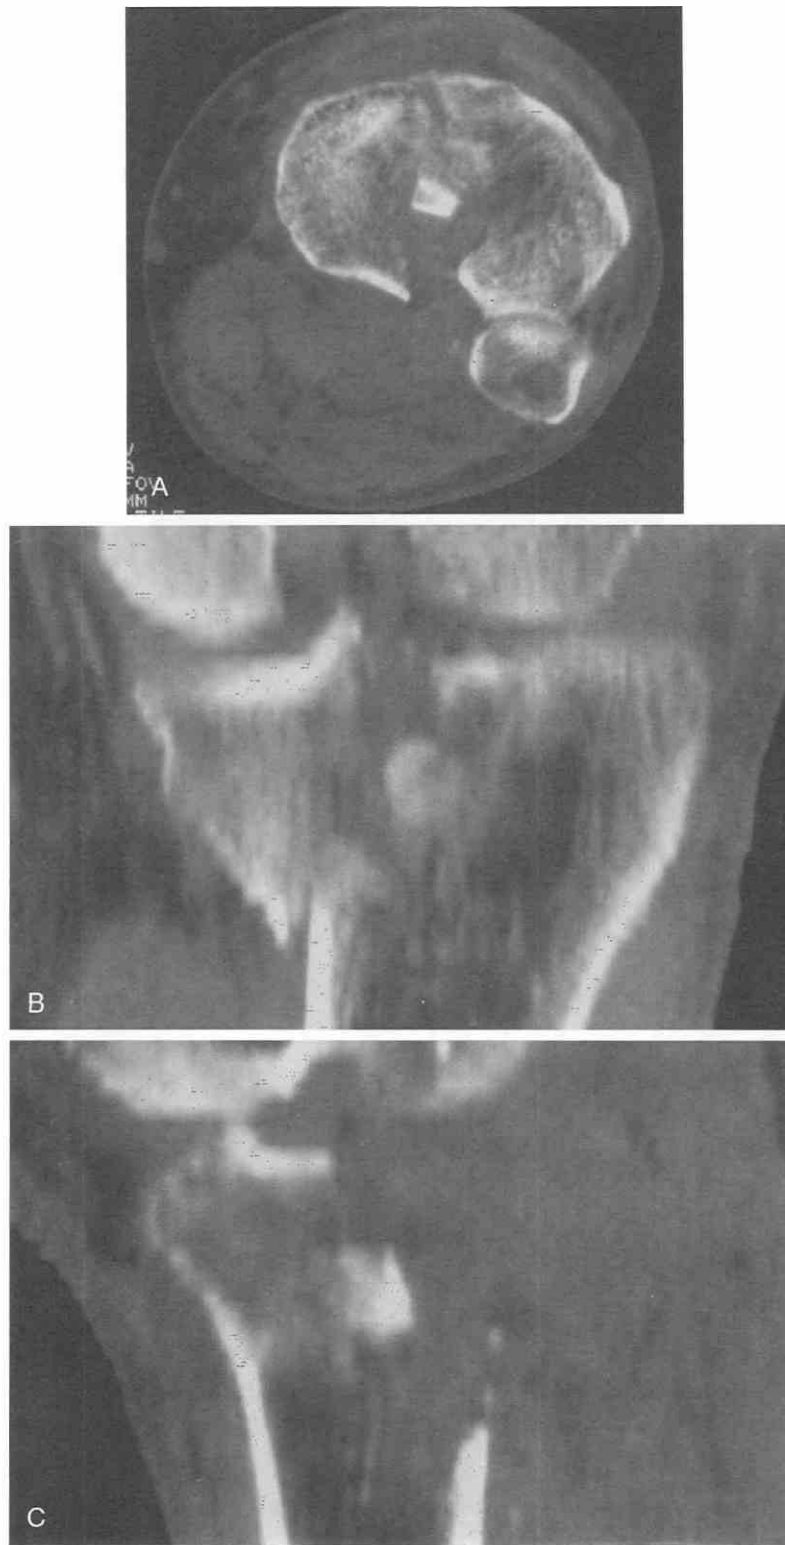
Tibial plateau fracture. Axial CT image with sagittal and coronal reconstructions shows the degree of comminution of the tibial plateau fracture. The central depressed fracture is well visualized and appears rotated.
